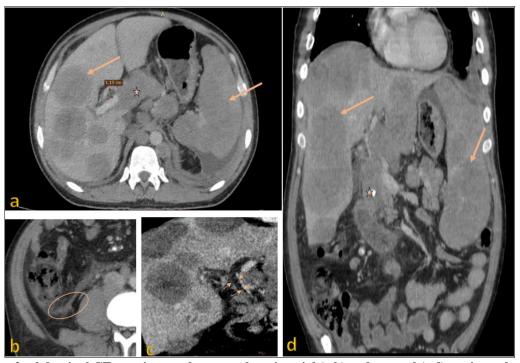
abdominal CT scan in portal venous phase in axial (a,b) and coronal (c,d) sections, showing hepatosplenomegaly with hepatosplenic macronodules (long arrow), dilatation of intrahepatic bile ducts and the main bile duct upstream of compression by adenopathy (short arrow), adenopathies with areas of necrosis and calcification (star) and nodular thickening of the peritoneum (circle)
